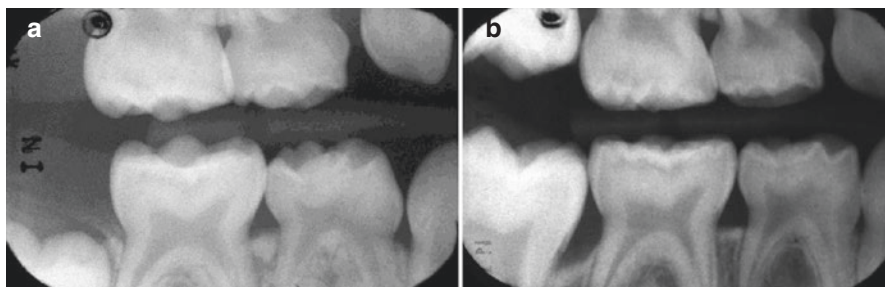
Sealing over occlusal carious lesions in primary molars. (a) Radiograph taken when the child was 5 years old showing initial carious lesions in all four first primary molars. These were sealed and radiograph (b) was taken 2 years later. There is no evidence of progression of any of the lesions
